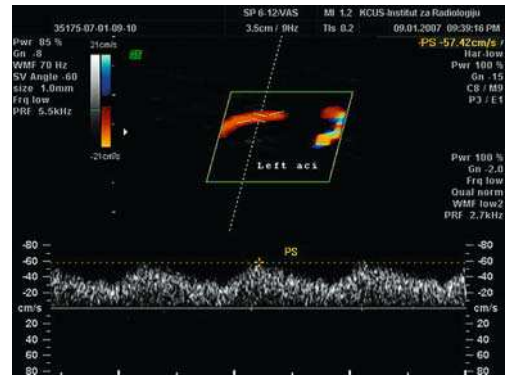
(a, b). Colour Doppler ultrasound (CD US) showing flow in the left internal carotid artery (LICI) and ACE above the occluded left common carotid artery (LCCA).
